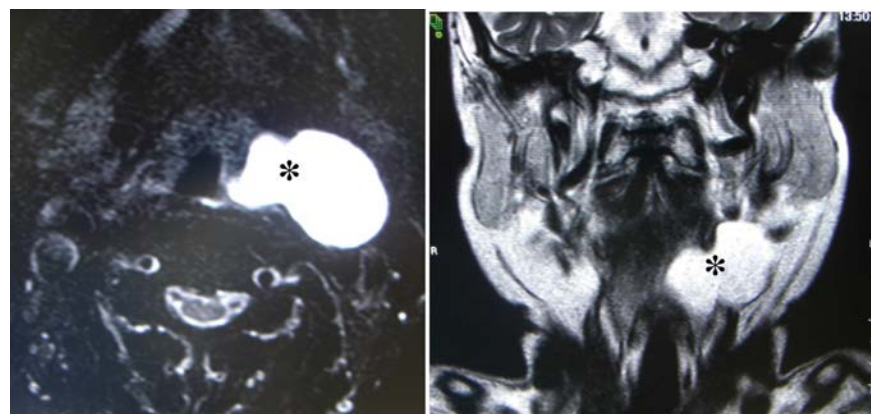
In magnetic resonance imaging, a dumbbell-type cyst with mucus (asterisks) could be observed from the laryngeal lumen through the thyroid cartilage to the neck.
